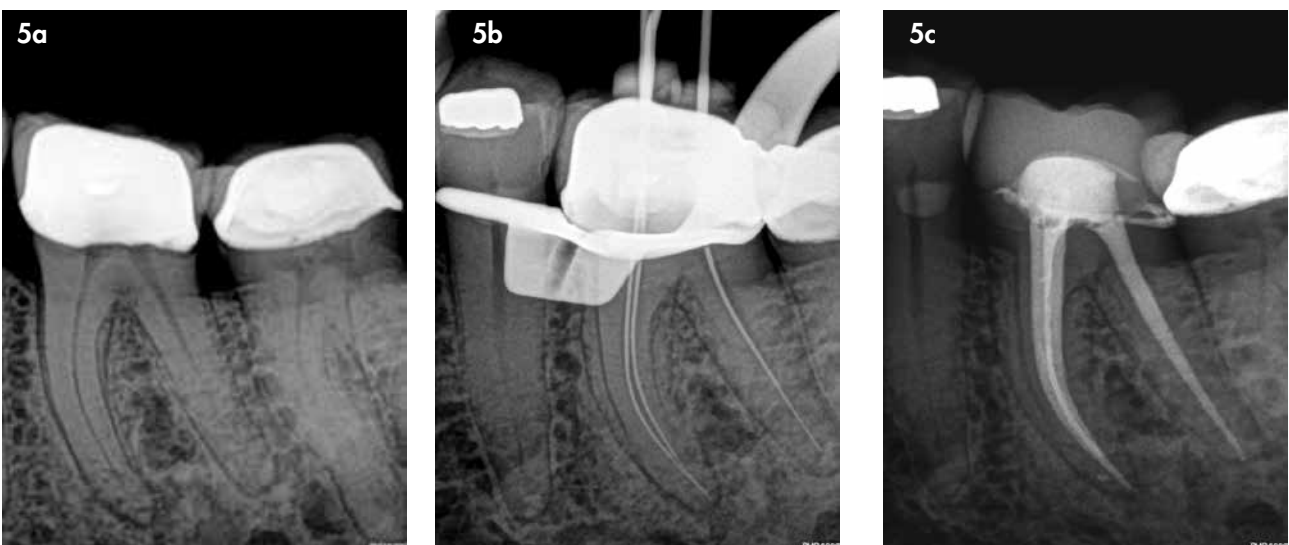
(a) Pre-operative periapical radiograph of non-vital mandibular left first molar; (b) Length determination periapical radiograph; (c) Postoperative periapical radiograph showing the result after obturation
